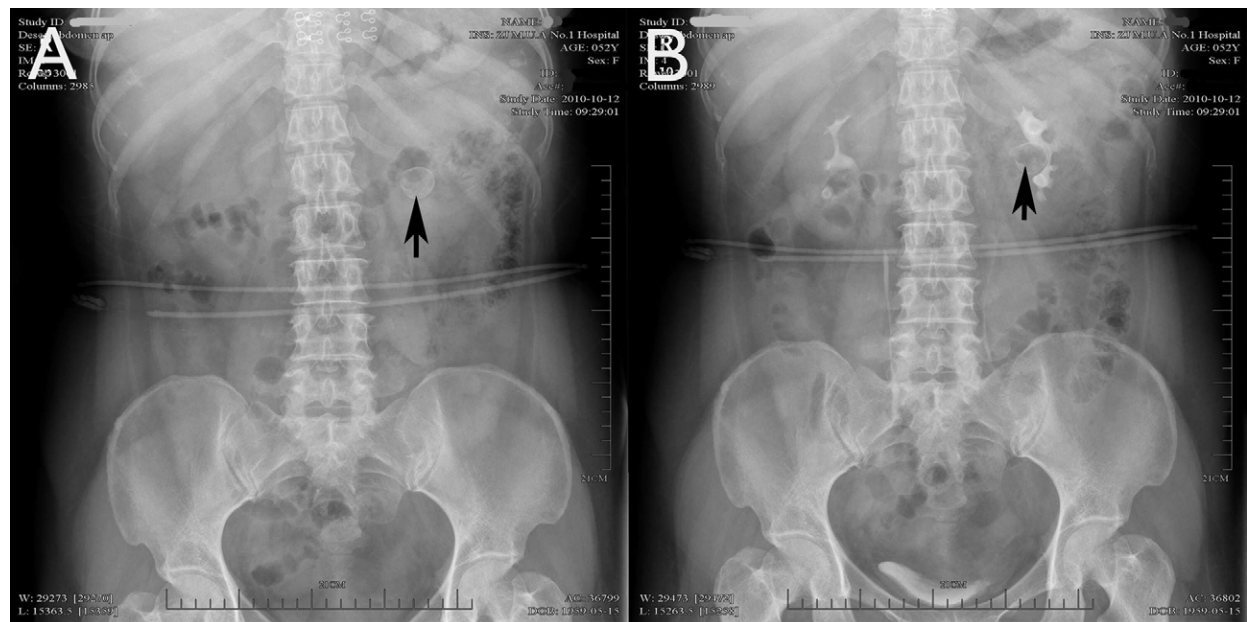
Images from intravenous pyelography. (A) A plain abdominal radiograph showed a left-sided renal calcification (arrow). (B) After injecting contrast medium, intravenous pyelography showed left hydronephrosis due to compression of the pyeloureteral junction by a 25-mm calcification (arrow).
